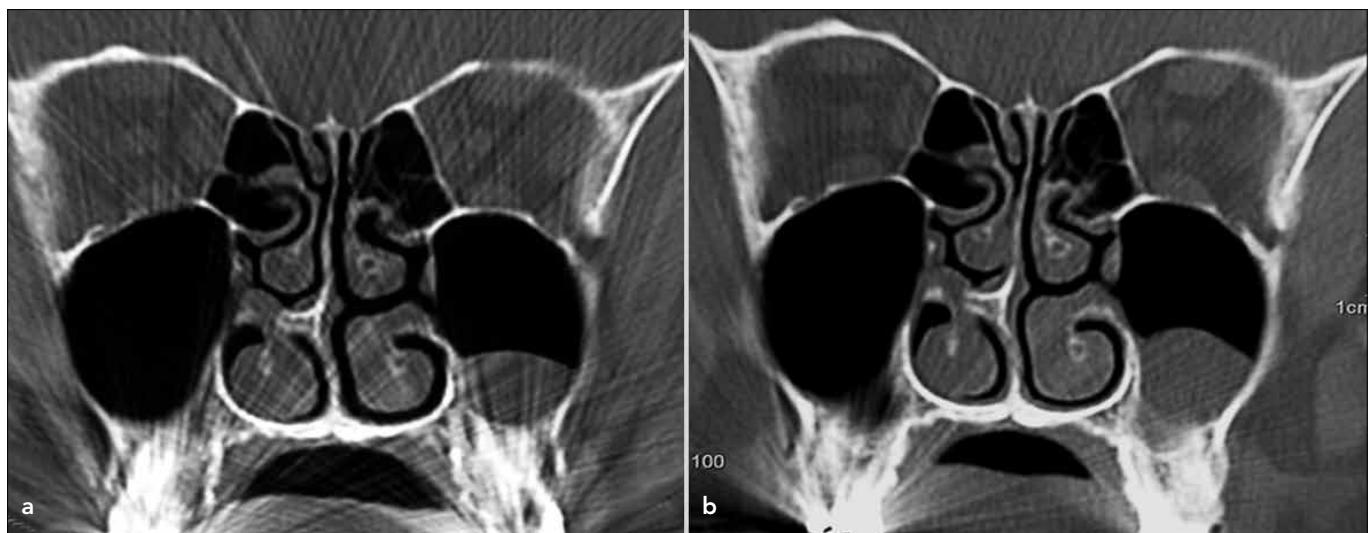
a, b. Coronal CT image (at the bone-window level) shows a homogeneous, dome-shaped cystic lesion with well-defined margin and low density consistent with retention cyst at the left maxillary sinus floor (a). One year later, follow-up CT image shows that the retention cyst increased in size (b).
